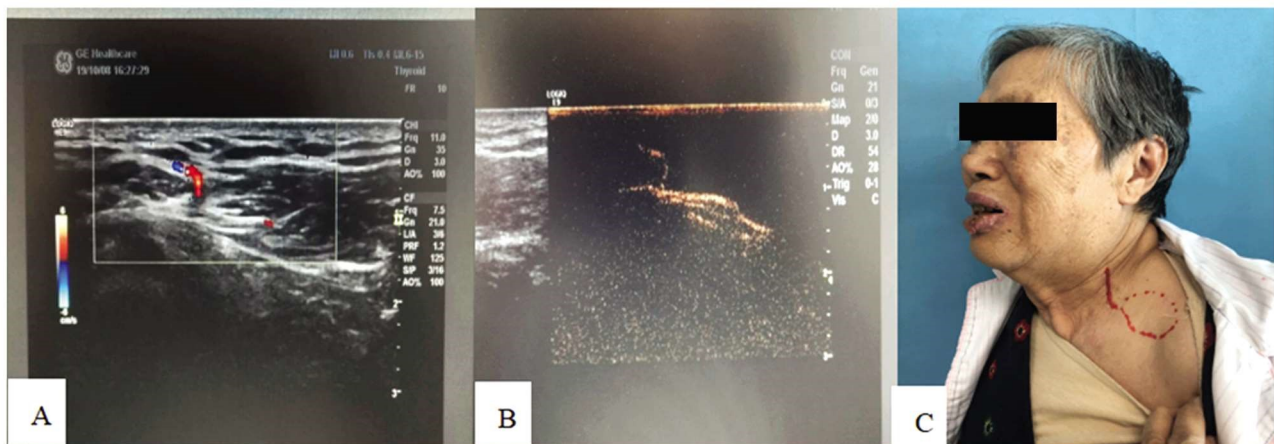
典型病例 CTA、CEUS 检查结果及血管走行标记
